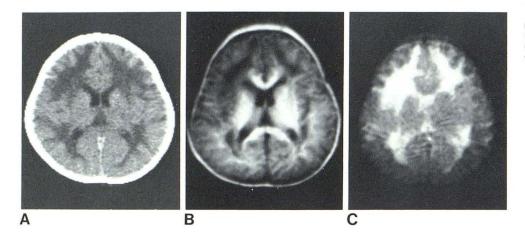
4-year-old with congenital muscular dystrophy. A, CT scan. B, $IR_{1800/600}$. Long T_1 areas in white matter. C, $SE_{1160/180}$. More extensive long T_2 in white matter.
